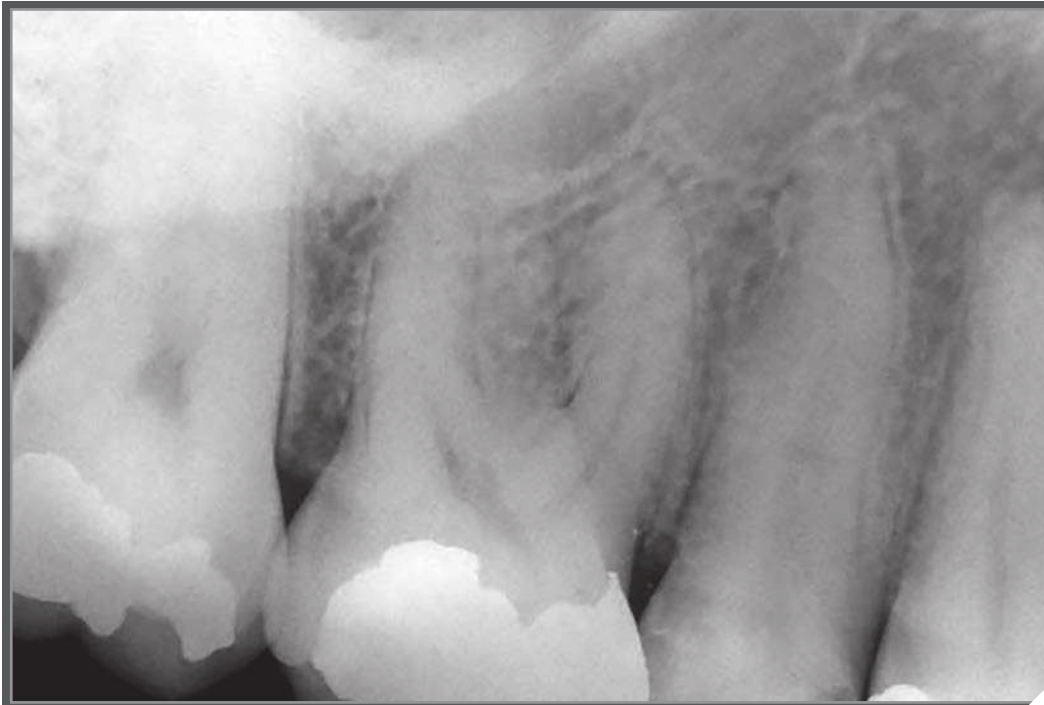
Preoperative radiograph.
